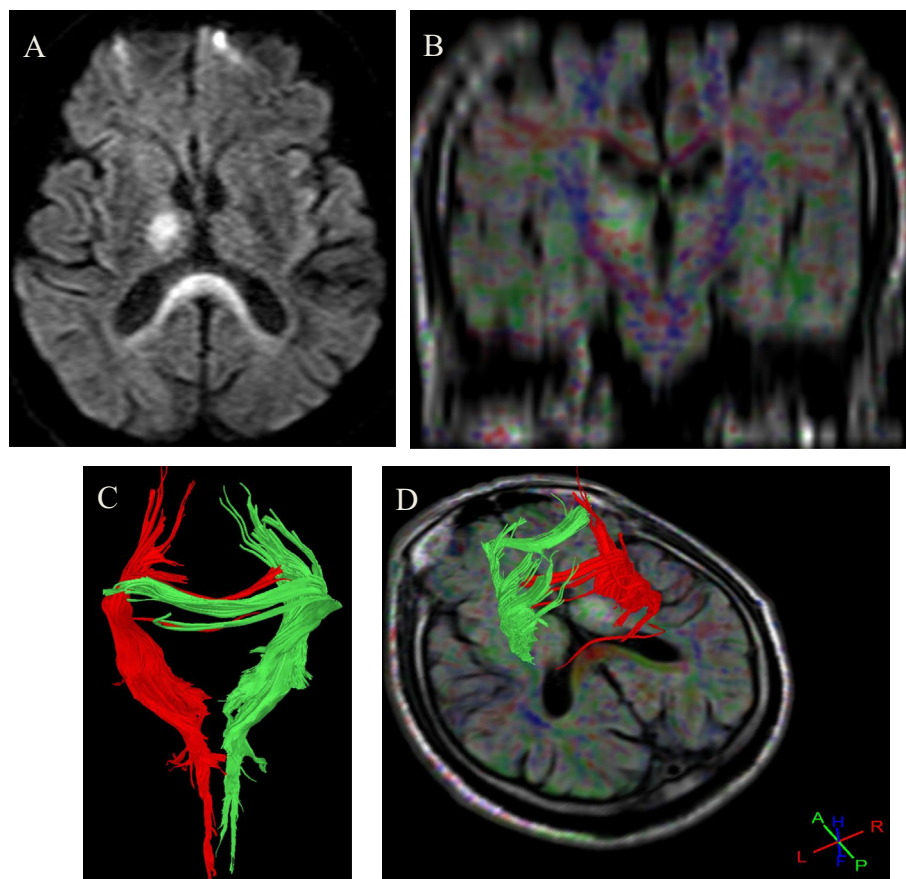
(A) Axial diffusion WIs (b1000) in a 45 years old male presented with left paresthesia shows right thalamic area of restricted diffusion (acute infarct). (B) Coronal FA color coded map overlaid over coronal FLAIR image. (C) 3D fiber tractography of the CST. (D) Axial FA color coded map overlaid over axial FLAIR image with 3D tractography of the CST showing preserved fibers of the right CST. Patient shows minimal residual sensory neurological deficit (NIHSS after 3 months was 2).
